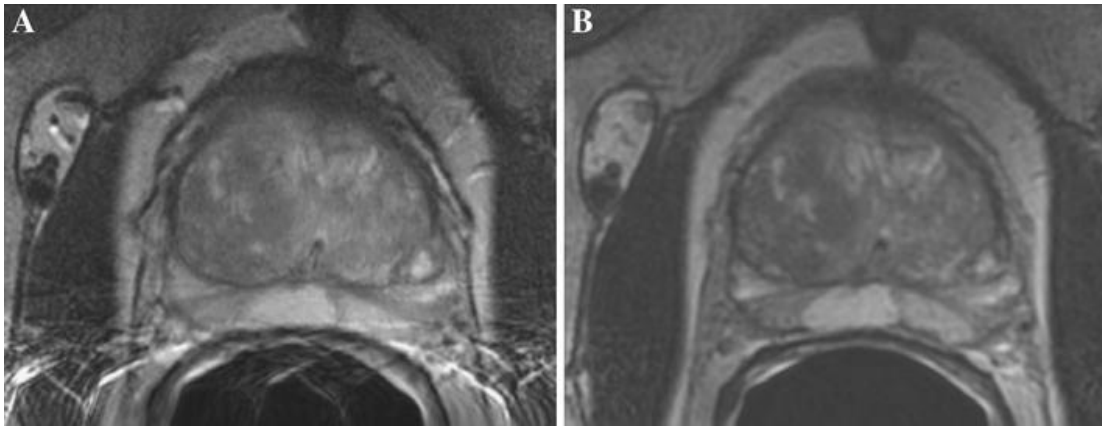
Comparison of 2D and 3D FSE T2-weighted MR images. An untreated 61 year-old man with biopsied Gleason 3+3 prostate cancer and serum PSA of 5.6 ng/ml showing an oblique axial a) T2-weighted FSE anatomic image and b) T2-weighted CUBE anatomic image. The phase-encoding direction aliasing artifact present in the FSE image is not present in the CUBE image. However, the CUBE image is noticeably blurred in comparison to the FSE.
